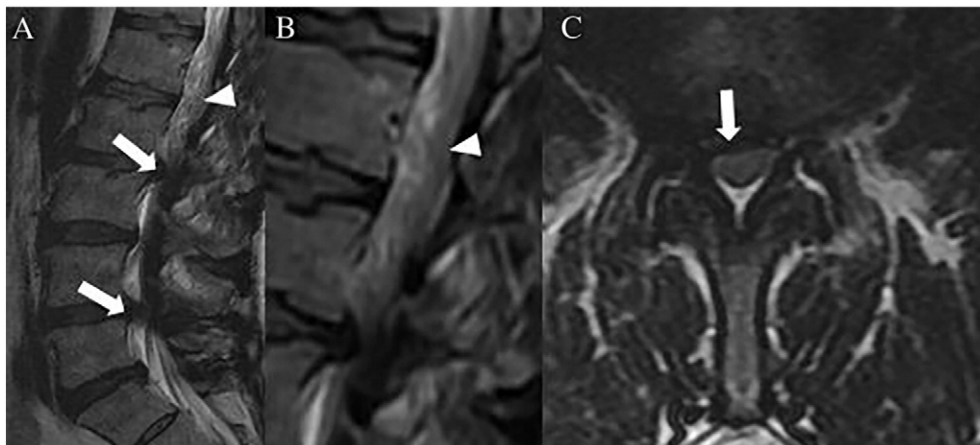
A, Sagittal T2-weighted magnetic resonance imaging (MRI) scan demonstrates degenerative changes of the lumbar spine with disk herniation and vertebral canal stenosis at L2/L3 and L4/L5 (arrows). Elongated and tortuous nerve roots of the cauda equina can be identified (arrowhead). B, Zoom demonstrating the redundant nerve roots (arrowhead). C, Axial T2-weighted MRI scan at the L2/L3 level demonstrating disk herniation with ventral thecal sac compression (arrow).
